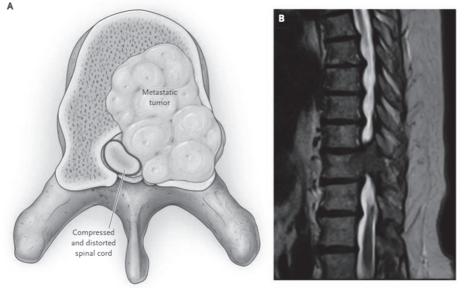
An example of non-traumatic spinal cord injury caused by a metastatic tumour in a thoracic spinal column. The tumour narrows the spinal canal causing distortion and compression of the spinal cord. On the right, a T2-weighted magnetic resonance imaging (MRI) scan shows metastatic renal cancer on the tenth thoracic spinal column, narrowing the spinal canal. Reproduced with permission from Ropper & Ropper (2017). Copyright Massachusetts Medical Society.
